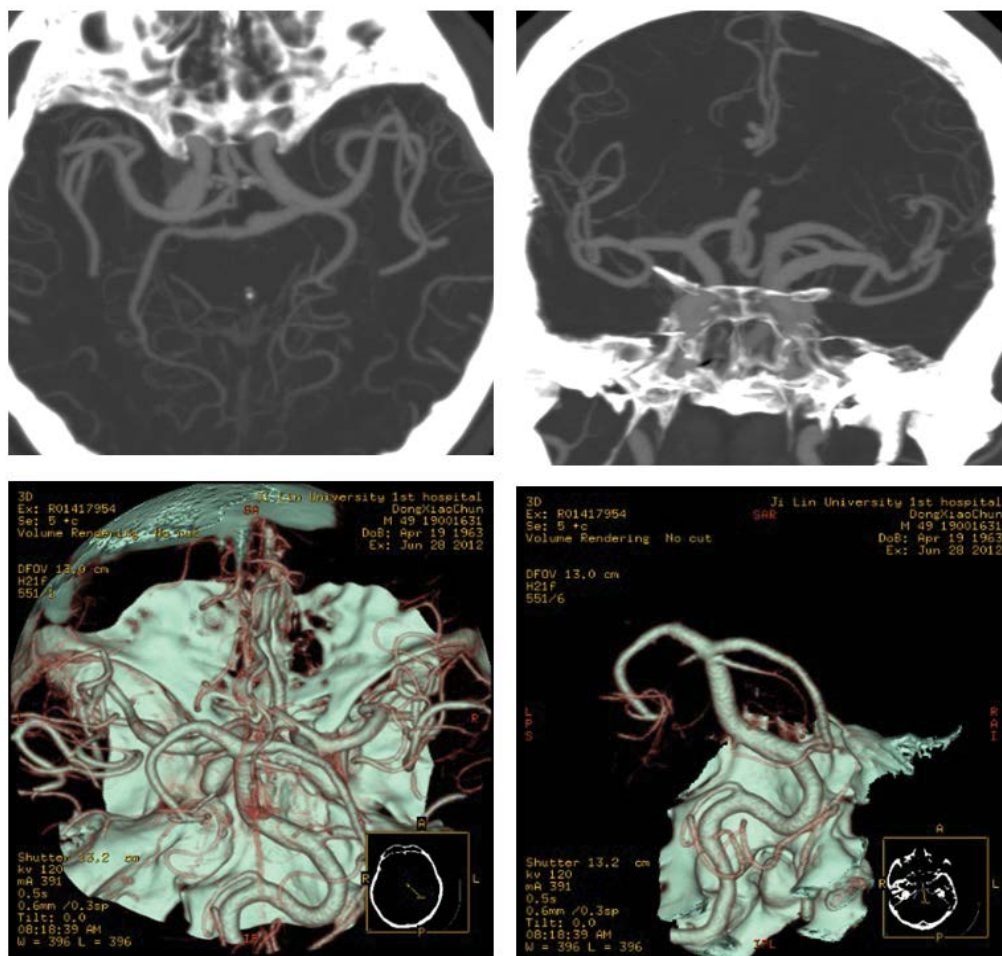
Computed tomography angiography indicated relatively large bilateral middle cerebral arteries and a modestly thin right vertebral artery. Computed tomography angiography indicated relatively large bilateral middle cerebral arteries and a modestly thin right vertebral artery.
